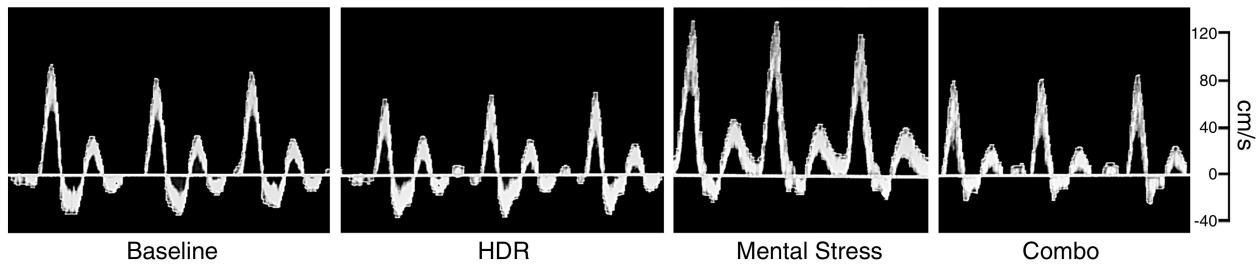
Ultrasonic-Doppler traces of forearm blood velocity from 1 subject during head-down rotation (HDR), mental stress, and combination trial (Combo). Forearm blood flow, as measured by forearm blood velocity and vessel cross-sectional area, decreased during HDR, increased during mental stress (MS), and did not change during the combination trial.
